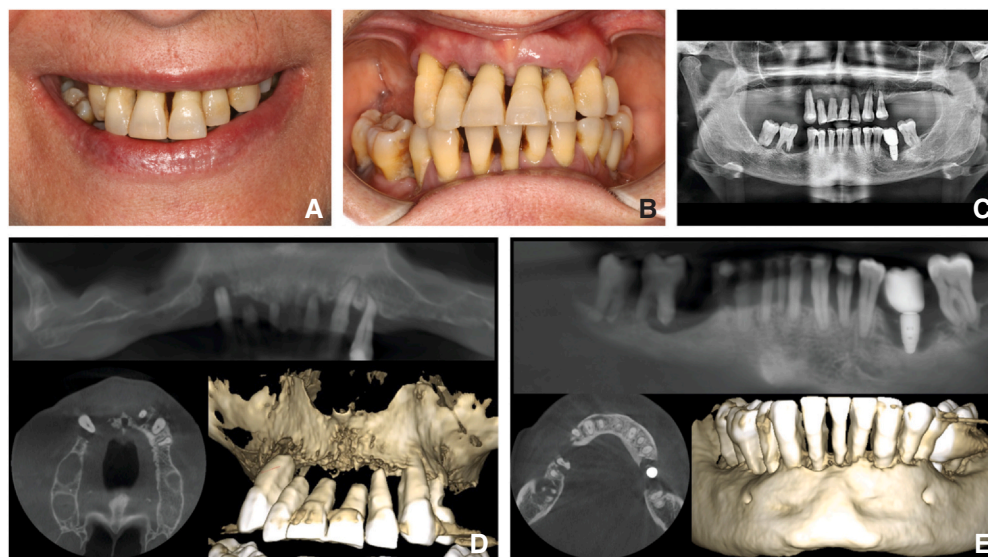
Initial evaluation. A, Smile. B, Maxillary and mandibular arches in MIP. C, Orthopantomography evaluation. D, Maxillary analysis using CBCT. E, Mandibular examination using CBCT. CBCT, cone beam computed tomography; MIP, maximum intercuspal position.
